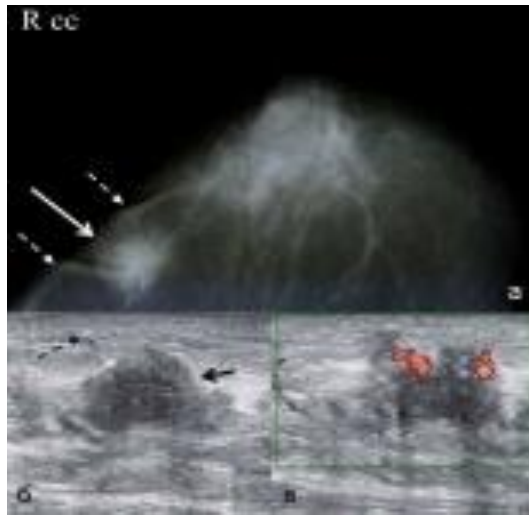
Patient E., 63 years old. X-ray mammography of the right breast in a direct projection (a), ultrasound (b), energy Doppler mapping (c). Invasive ductal breast cancer. The formation of an irregular shape with heavy contours, an inhomogeneous structure (solid arrow) with thickening of the skin (dashed arrow) is determined. With energy Doppler mapping, blood flow is determined by a mixed type
